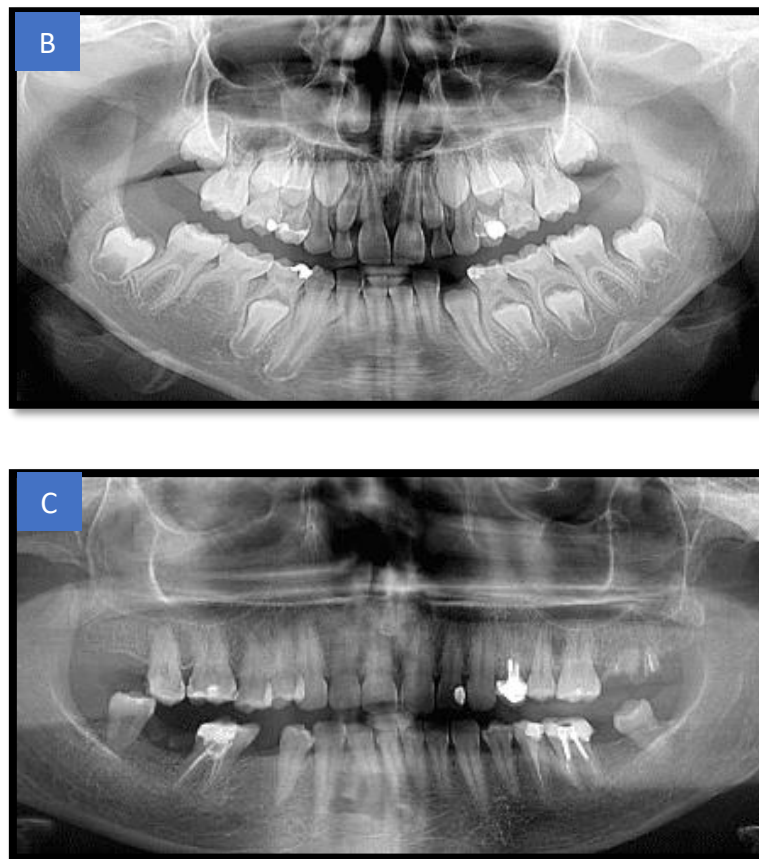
Radiographic of a Romanian sub-population family with unique case of tooth agenesis
